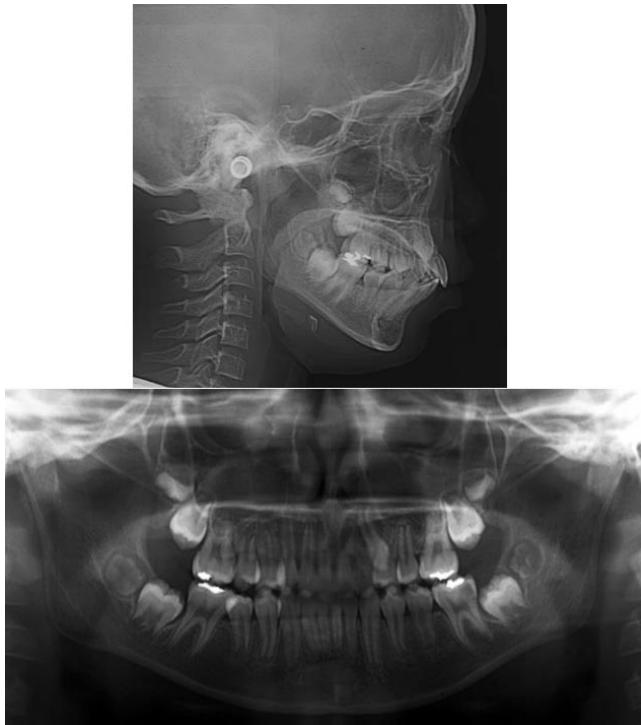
Cephalometric and panoramic radiographs before treatment (11 years one month old).
